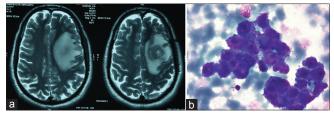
(a) Magnetic resonance imaging of the brain showing heterogeneous lesion in the left posterior frontal region. (b) Cytological smear showing atypical lymphoid cells with plasmablastic differentiation (May-Grunwald-Giemsa, ×400)
